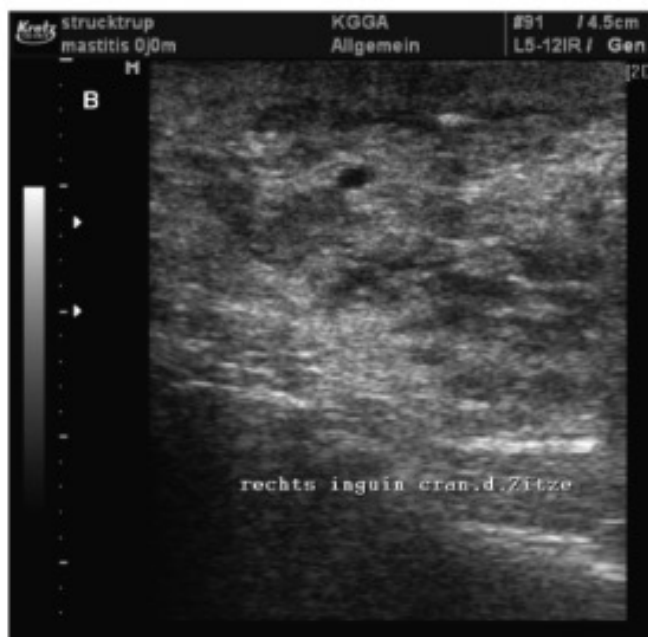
Transverse ultrasound image of a normal lactating gland (A) and of an inflamed lactating canine gland (B). The loss of separation between tissue layers is apparent in (B). The lines in the image in (A) indicate the skin (a), parenchyma (b), fascia (c), and muscle (d). The glandular parenchyma is coarse-grained and of medium echogenicity 152 × 101 mm (300 × 300 DPI).
